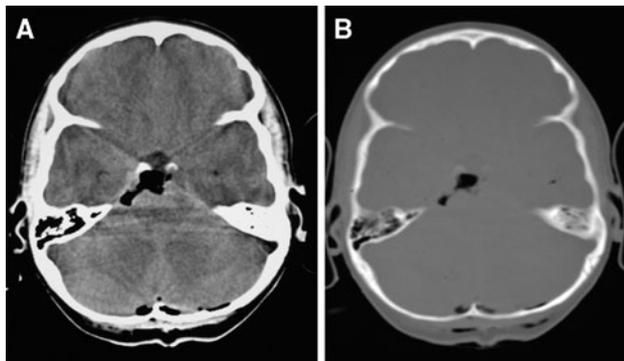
Case 4. A 10-year-old boy who underwent decompression of a Chiari I malformation. Following surgery, he was lethargic, with a dilated left pupil. A non-enhanced CT scan demonstrated pneumocephalus in the interpeduncular cistern with some mass effect on the anterior right midbrain on soft tissue window (a) and bone window (b)
